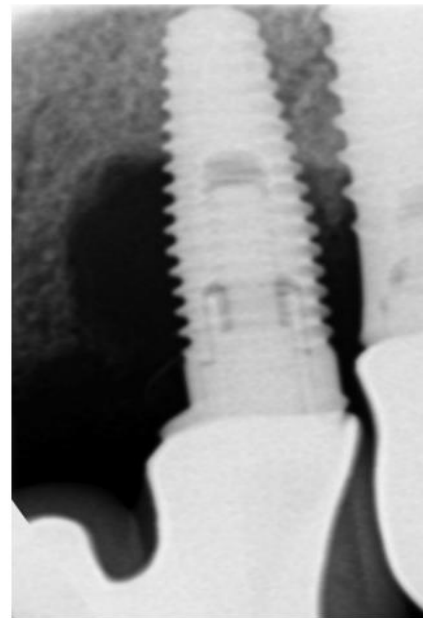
Peri-implantitis, Bacterial Etiology (maxillary anterior incisor) periapical radiograph: Alveolar crest levels appear radiopaque. Severely reduced abrupt vertical bone loss noted at mesial and distal aspect of implant housing. Image provided by authors.
